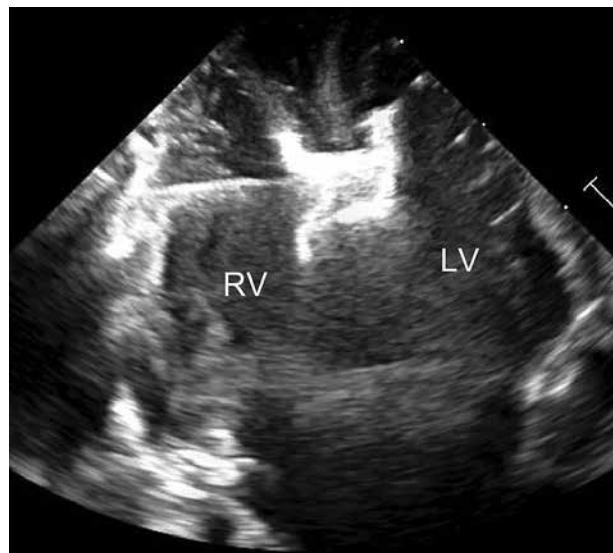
Epicardial echocardiography. 7 mm Hyperion VSD Muscular Occluder deployed in VSD over delivery cable
